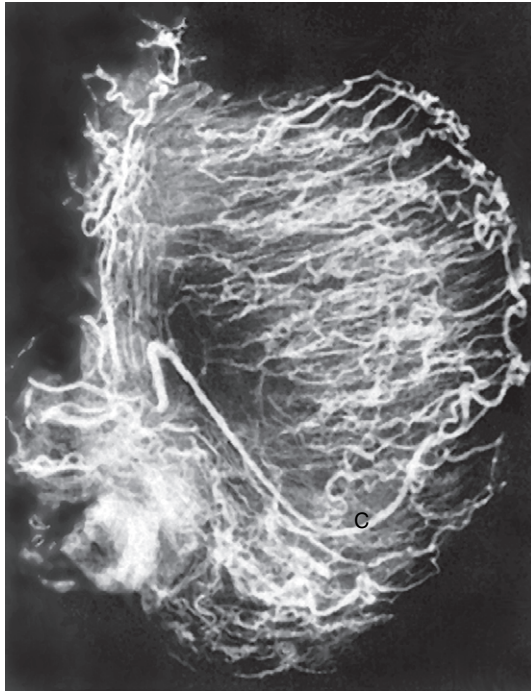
Microangiogram of the testicle. A prominent capsular branch (C) courses from the testicular artery under the capsular surface. Centripetal arterial branches emanate from it and pass into the lobules of the testicle. With very sensitive Doppler settings, a series of centripetal arteries is seen across this normal testicle. Case courtesy of Dr. Thomas Winter.
